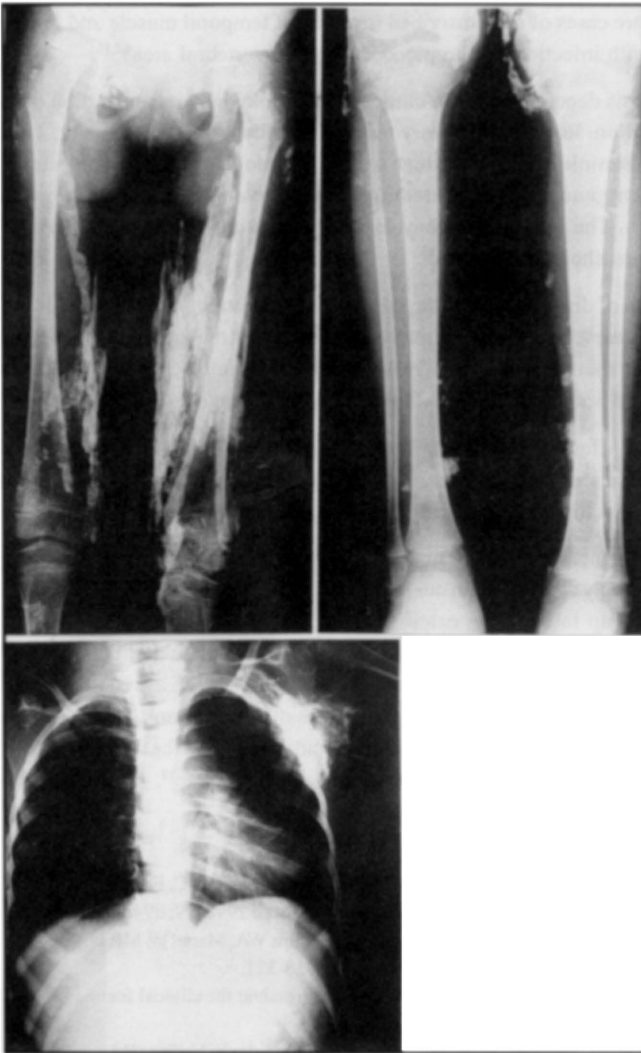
Patient SSM. Radiographs show ectopic bone in: A) hips and thighs; B) legs; C) left shoulder.
